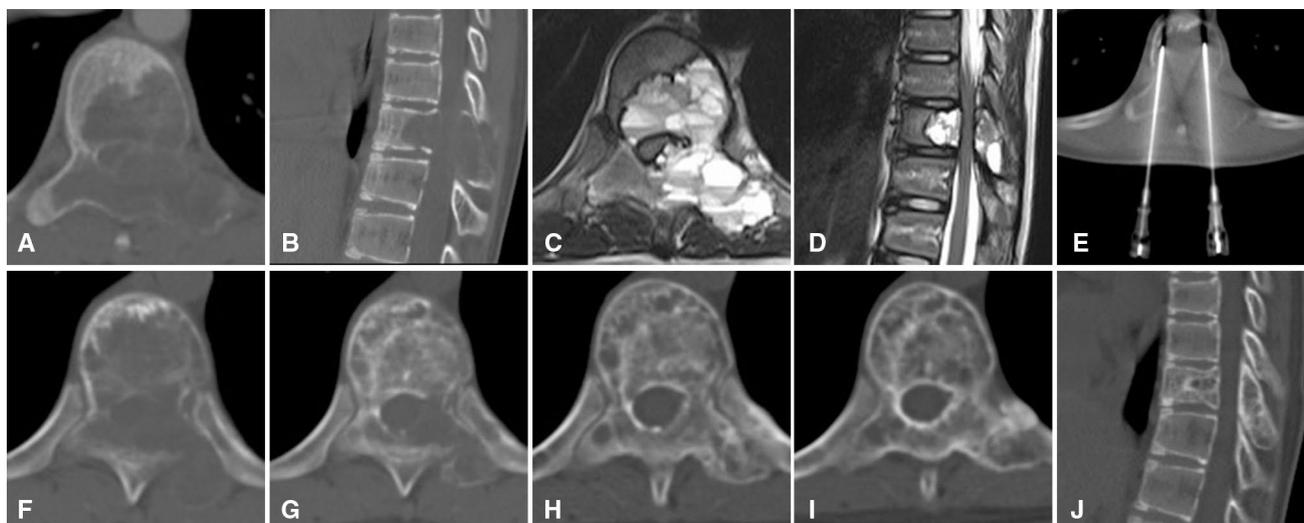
Representative case of a 14-year-old girl who experienced back pain for 5 months and was diagnosed as having an aneurysmal bone cyst of T10, which was treated with 3 percutaneous doxycycline/albumin injections. a and b Axial and sagittal CT scans showed an osteolytic lesion involving the vertebral body and neural arch. c and d Axial and sagittal T2-weighted magnetic resonance imaging scan revealed a polycystic lesion with fluid–fluid levels. e Two
